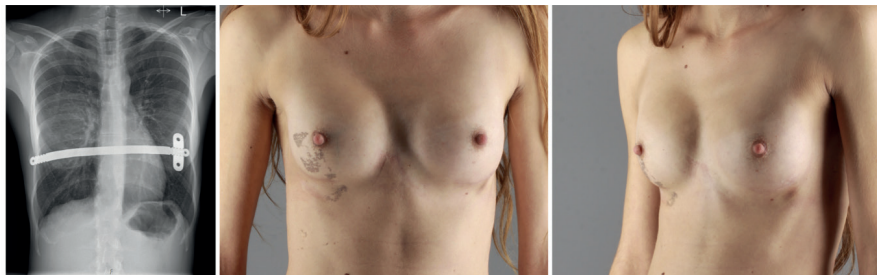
Patient D. Postoperative anteroposterior chest radiograph and optical result after MIRPE and breast augmentation.
